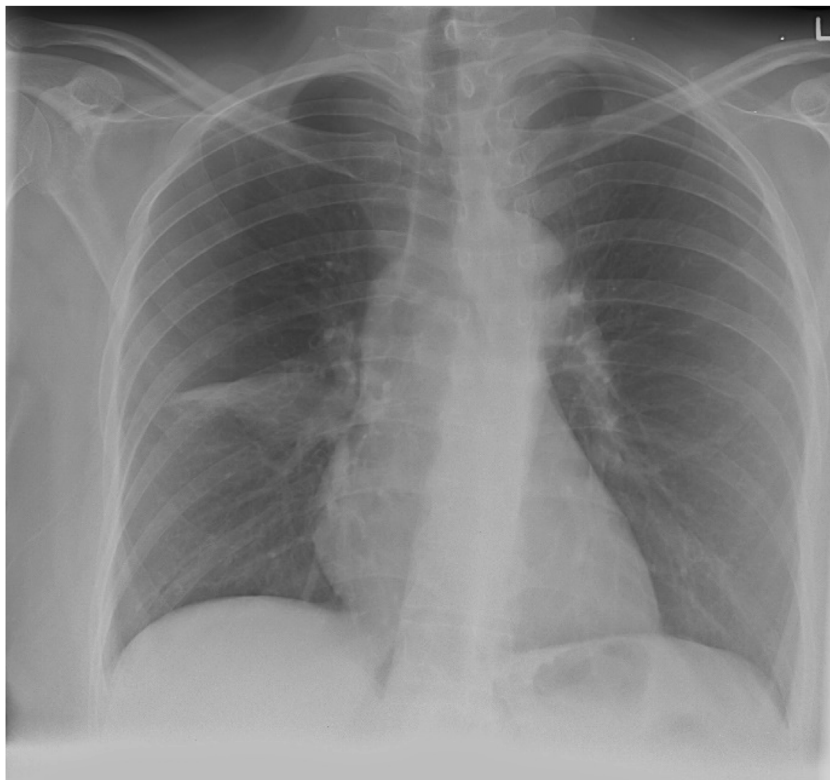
Chest Radiograph shows an opacity in the right midzone with an ovoid, well-defined fluid density structure in the superior aspect of the right middle lobe measuring 3.4×2 cm in maximal axial dimensions.
